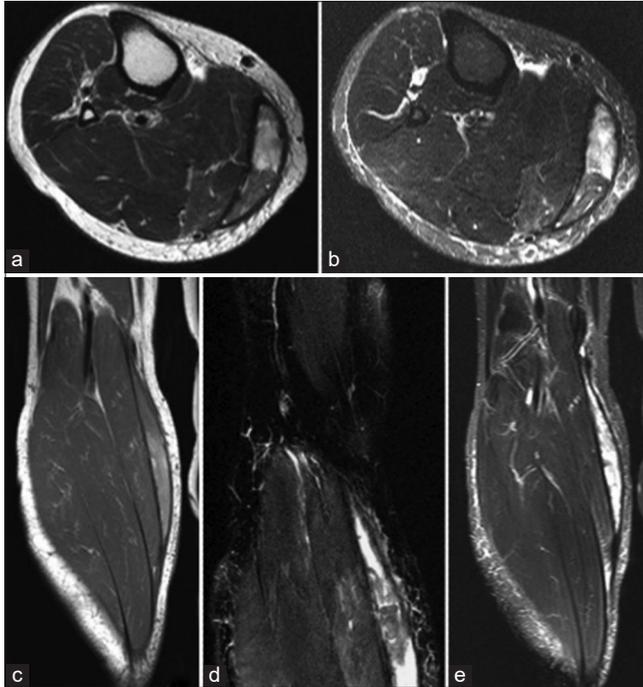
Axial T1 (a) and short tau inversion recovery (STIR) (b) magnetic resonance imaging (MRI) with coronal T1 (c) and STIR (d and e). The patient in Figure 12 underwent a subsequent MRI after clinical review, which confirmed a thick-walled mixed high and low signal intensity collection medial to the medial head gastrocnemius in keeping with a ruptured Baker’s cyst with internal hematoma.
